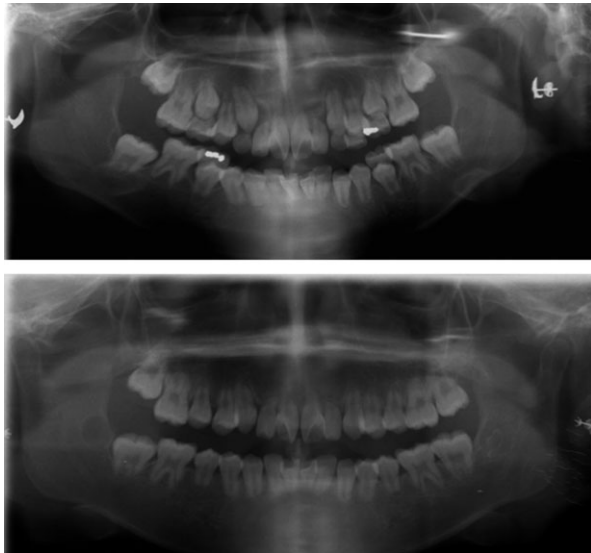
The panoramic radiographs of the same female reported in Figure 2 at age 9 and 12.
